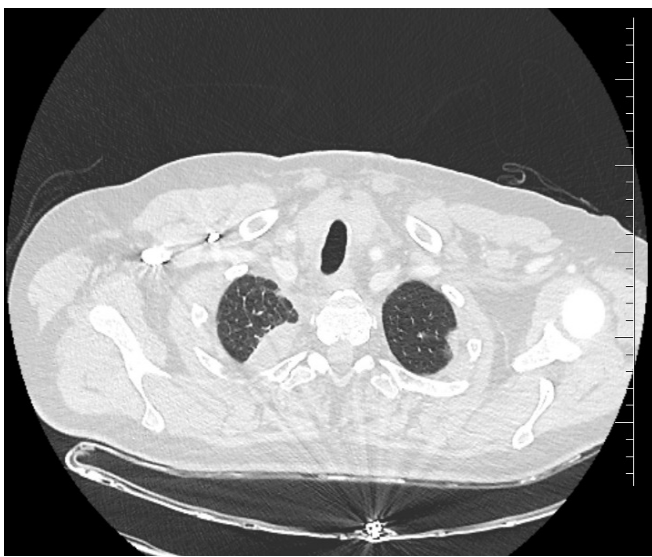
An axial CT scan demonstrating a superinfected lung cyst in right apical segment.
